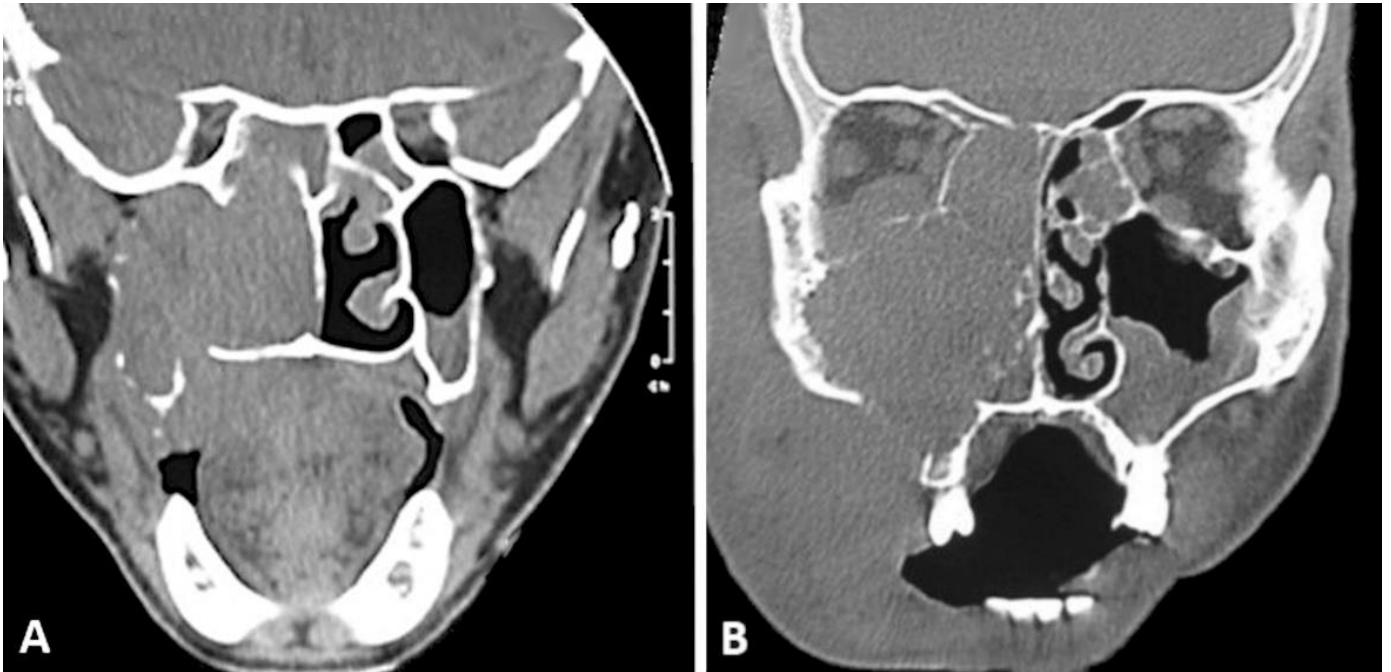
Coronal view of multislice computed tomography. A) Case of DLBCL, NOS with hypodensity and disruption of right maxillary sinus walls, with opacification with soft tissue density in right maxillary sinus and nasal cavity extending towards the palate. B) Case of plasmablastic lymphoma with hypodensity and disruption of right maxillary sinus walls, inferior orbital wall, with opacification with soft tissue density in right maxillary sinus, ethmoid cells and nasal cavity. The tumor extended to the oral cavity through destruction of maxillary bone.
